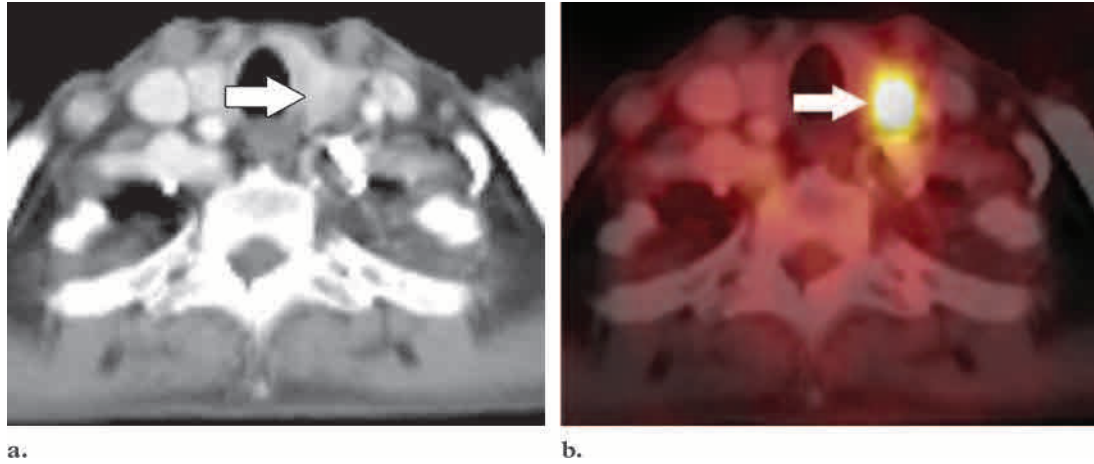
Hypermetabolic thyroid adenoma. Axial CT (a) and fused PET-CT (b) scans show focal intense FDG uptake (arrow) that is localized to the left lobe of the thyroid gland. Subsequent biopsy helped confirm thyroid adenoma.
